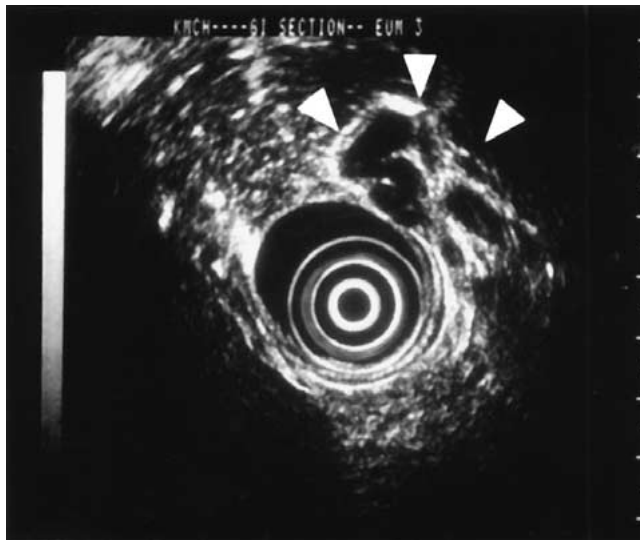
Endoscopic ultrasonography (EUS) showing grade 3 fundic-type gastric varices (GV) (arrowheads).
